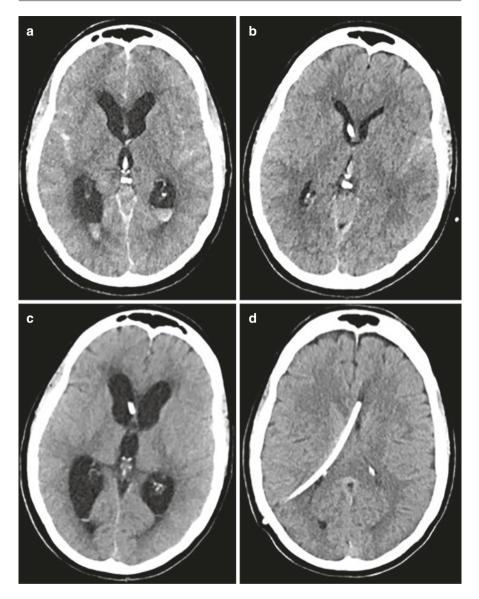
Acute hydrocephalus requiring a ventriculoperitoneal shunt. A 49-year-old female presenting with a Hunt and Hess grade 3, Fisher grade 3 SAH secondary to a ruptured basilar apex aneurysm and acute hydrocephalus (a), managed with a ventriculostomy (b). Following 2 weeks of CSF drainage, the patient did not clinically or radiographically tolerate an EVD clamp trial (c), requiring placement of a VP shunt (d). *SAH* subarachnoid hemorrhage, *CSF* cerebrospinal fluid, *EVD* external ventricular drain, *VP* ventriculoperitoneal
